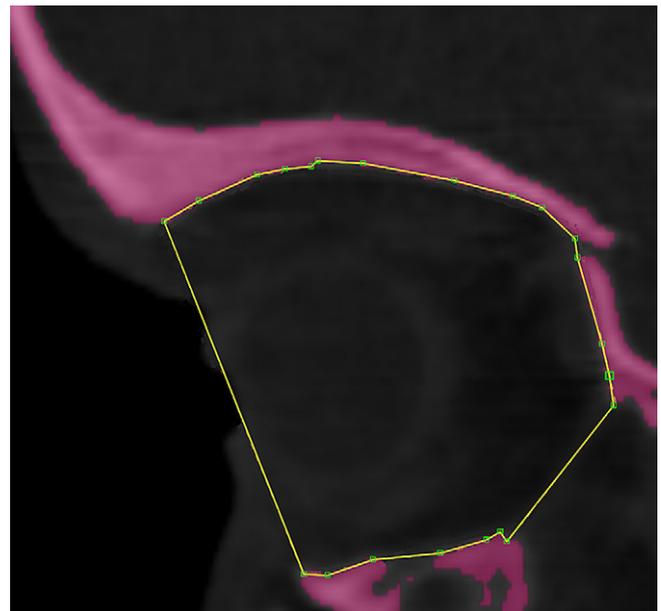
The anterior boundary defined as a straight line from the most antero-cranial point of the infra-orbital rim to the most antero-caudal point of the supra-orbital rim is depicted in a sagittal CT-slice. Furthermore, bony interruptions of the orbit are evident. A perpendicular straight line was manually drawn between the most nearby bony boundaries.
